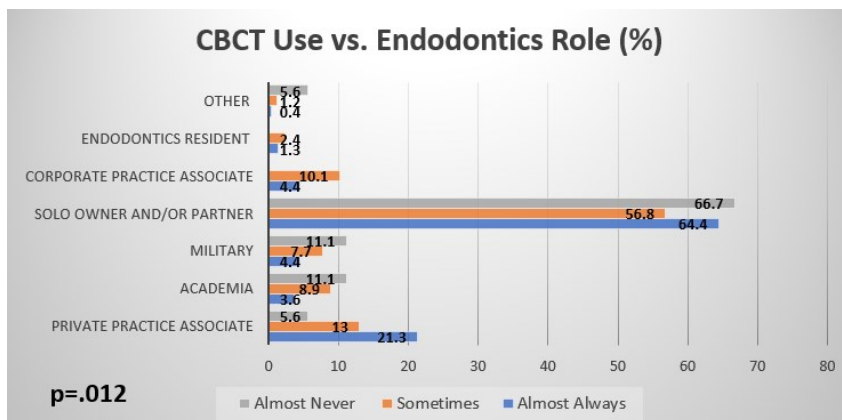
Data comparing the frequency of CBCT use and the endodontics role.
